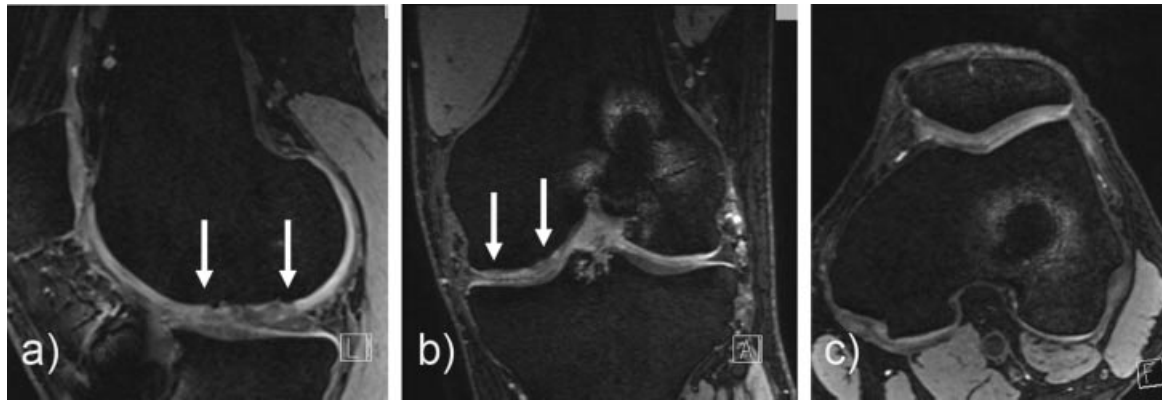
Morphological, isotropic, 3D-DESS sequence of the same patient 15 months after MACT surgery (1-year follow-up MRI). Multiplanar reconstruction of sagittal (a), coronal (b), and axial (c) plane; arrows mark the area of cartilage repair.
